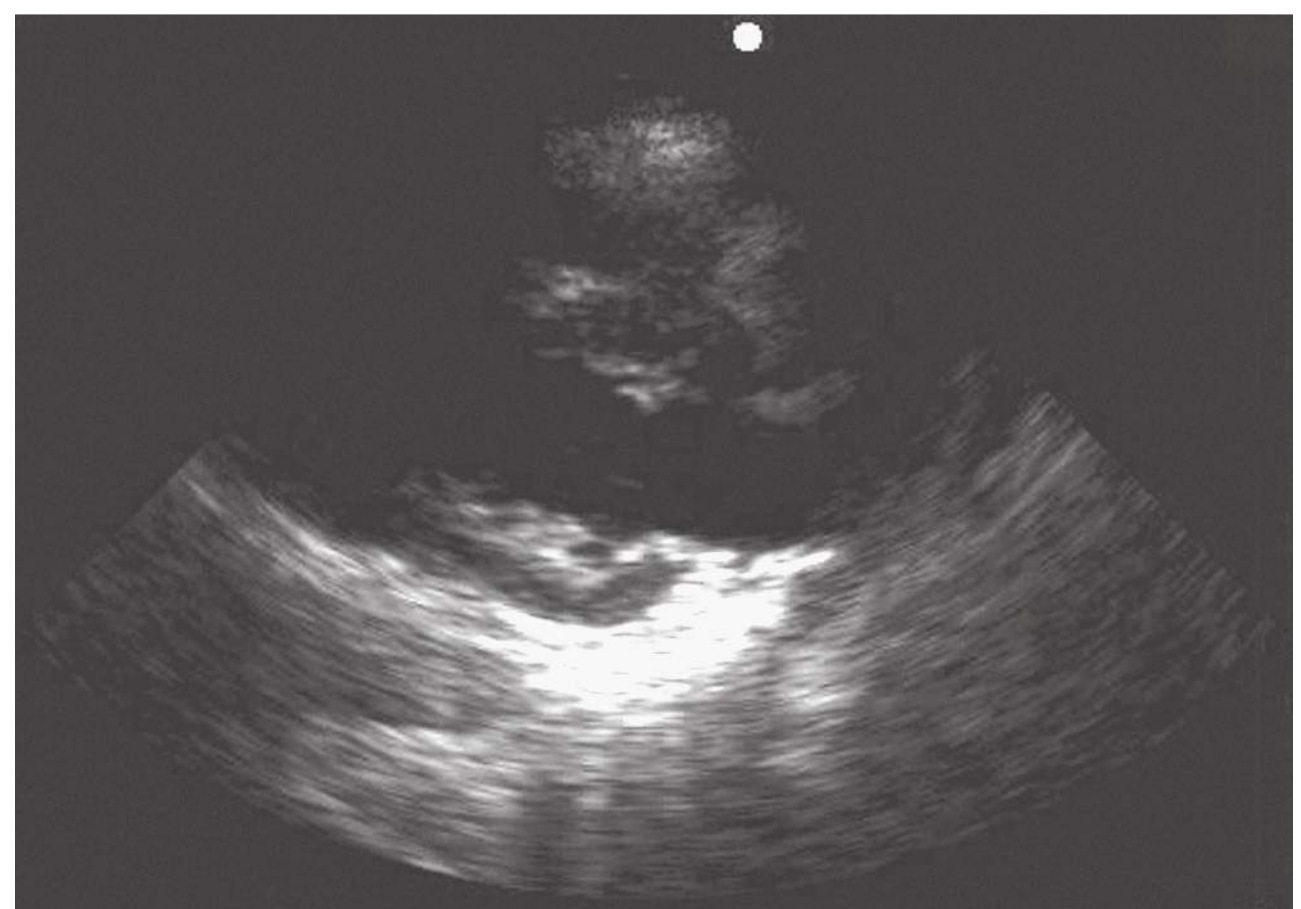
Parasternal long-axis view, normal ejection fraction, normal mitral valve (MV) motion. Parasternal long-axis view during mid-diastole showing maximal MV opening in a heart with normal systolic function. Note the anterior MV leaflet almost touching the septum.
